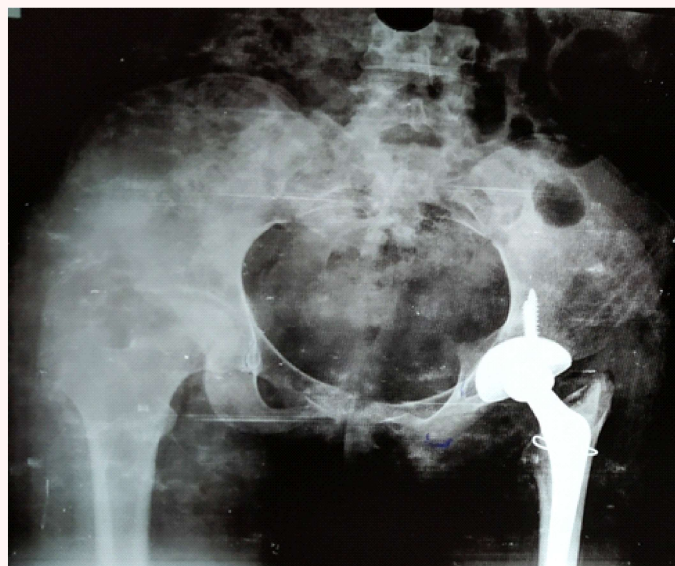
Post-operative pelvic both hip X-Ray of the patient after total hip replacement
